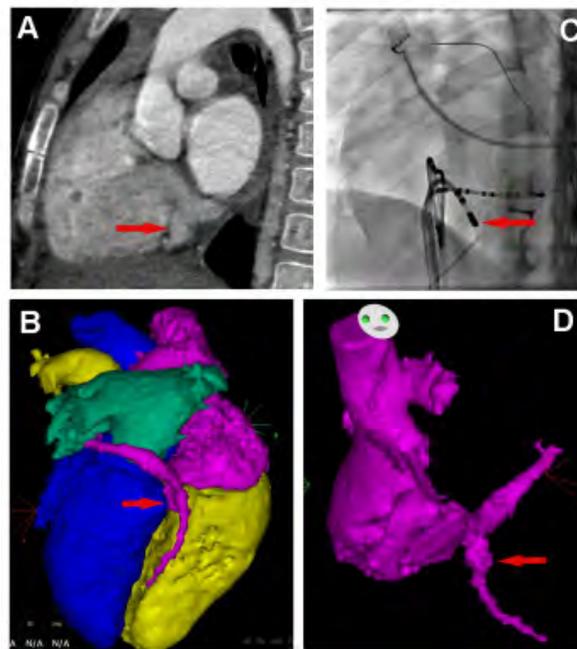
Cardiac CTA with segmentation. The red arrow in all figures shows the diverticular dilation of the proximal MCV. (A) Sagittal view of the heart. (B) Segmentation of the cardiac CTA using the Carto 3 mapping system. The heart is shown in a posterior inferior view. The right atrium and coronary venous system are presented in purple, the right ventricle and pulmonary artery in yellow, the left atrium in green and the left ventricle and aorta in blue. (C) Left anterior oblique fluoroscopic view of the intracardiac catheters with the ablation catheter at the proximal portion of the CS diverticulum (successful site of ablation). (D) The segmented right atrium and coronary venous system shown alone. CTA = computed tomogram angiography; MCV = middle cardiac vein.
